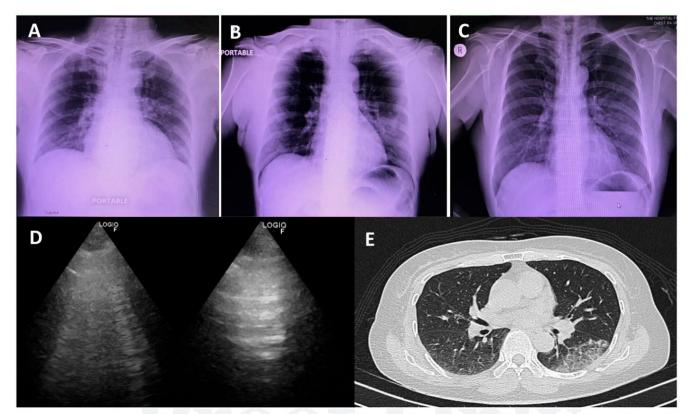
Three modalities of chest imaging studies in coronavirus disease 2019 patient. Chest radiographies (A, B, and C) were obtained on February 3, 8, and 14, 2020; chest ultrasonography and axial high-resolution computed tomography were obtained for the follow-up lung lesion on February 14, 2020.
